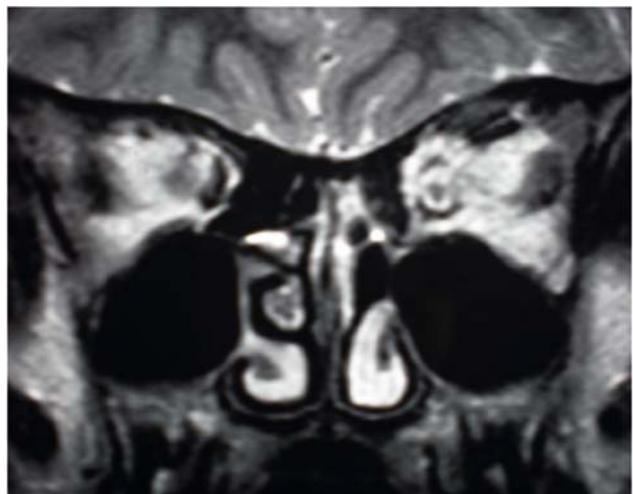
Preoperative coronal CT scans showing fungal lesion in the orbital apex
